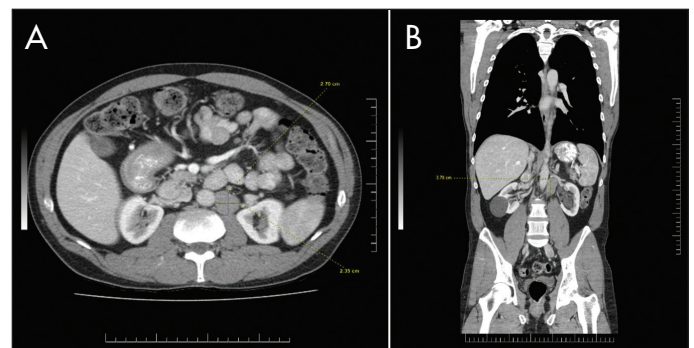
Case 3: Stage 2 B seminoma. Computed tomography demonstrating 3.7 cm node in left para-aortic region.
